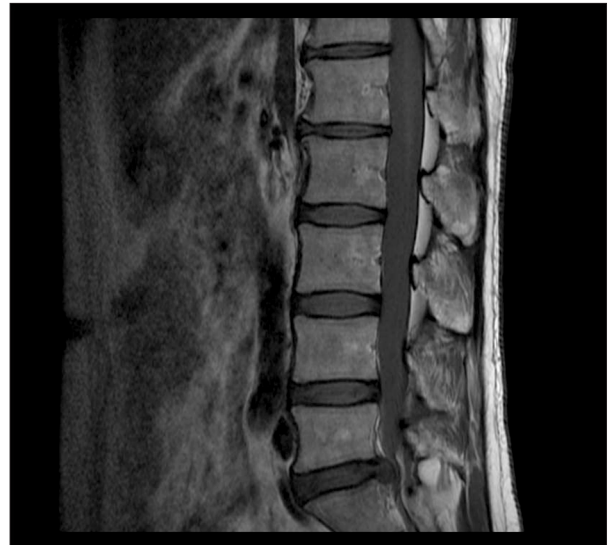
MRI image of the spine shows L5–S1 disc extrusion causing compression of the left S1 traversing nerve root and nerve root edema.
